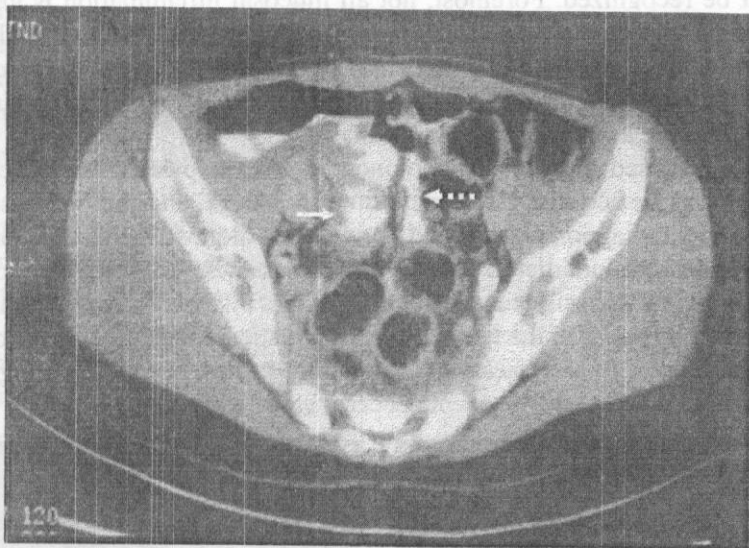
Computed tomography scan from a patient with terminal ileal Crohn's disease shows an enteroenteral fistula (arrow) between loops of diseased small intestine.
